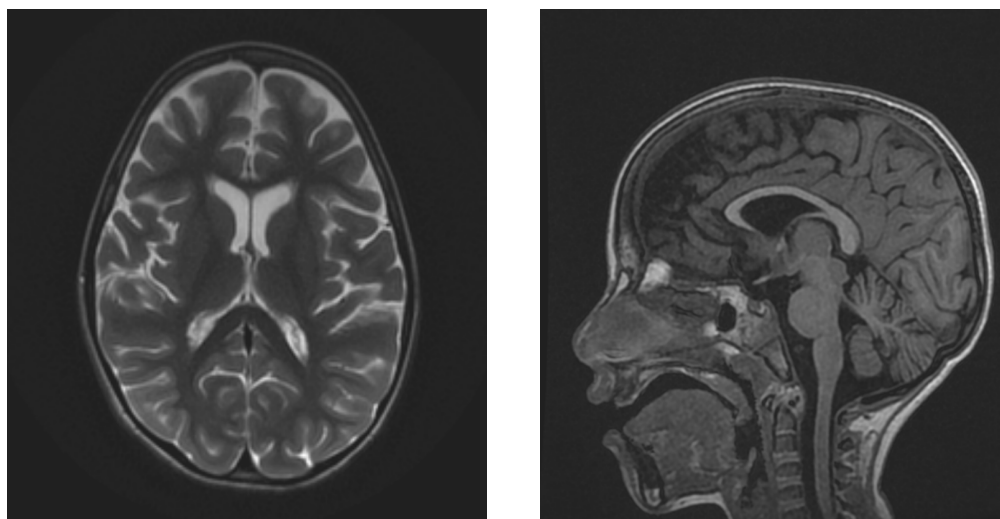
Brain MRI of the second patient: (a) T2-weighted axial image showing cortical thinning; (b) T1-weighted sagittal image showing minimal cerebral and cerebellar atrophy
